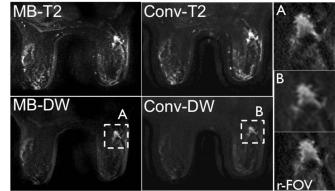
Comparison between MB, conventional (Conv) and r-FOV DWI
